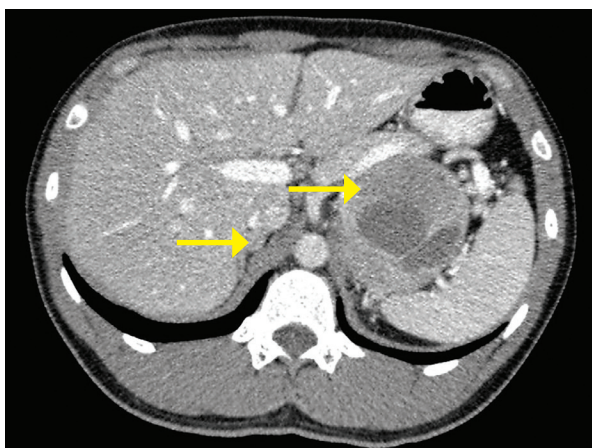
Axial view of the contrasted adrenal-directed CT during the venous phase showed bilateral adrenal masses of lipid-poor content, measuring in size [left: 7.1 x 7.5 x 7.4 cm; right: 2.0 x 1.1 x 1.8 cm] (yellow arrows).
